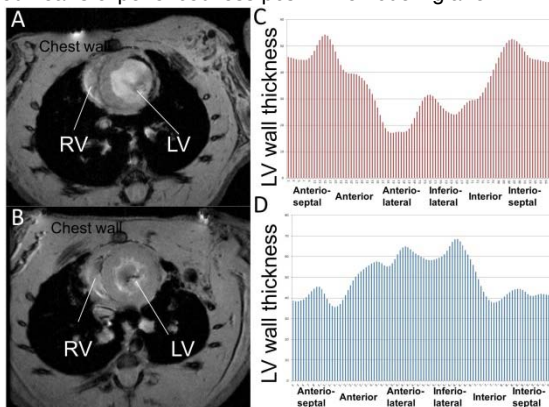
(A,B) Anatomical MRI of an untreated heart at 3 weeks after ischemic injury (A) and an Intralipid-treated heart at 3 weeks after ischemic injury (B). (C,D) Distance between endocardium and epicardium at 100 different locations of the myocardium, starting at the mid-point of the septum, going counterclockwise direction for the untreated heart in A (C), or the Intralipid-treated heart in B (D). Different myocardial regions are indicated as anterior-septal, anterior, anterior-lateral, inferio-lateral, interior, and inferio-septal wall.
